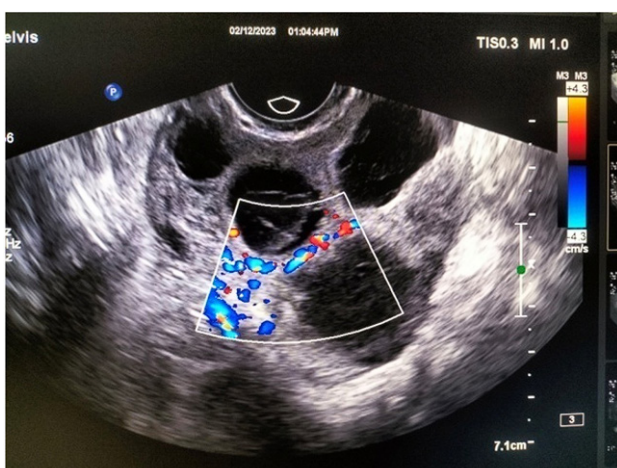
Right ovary showing normal flow on colour doppler
